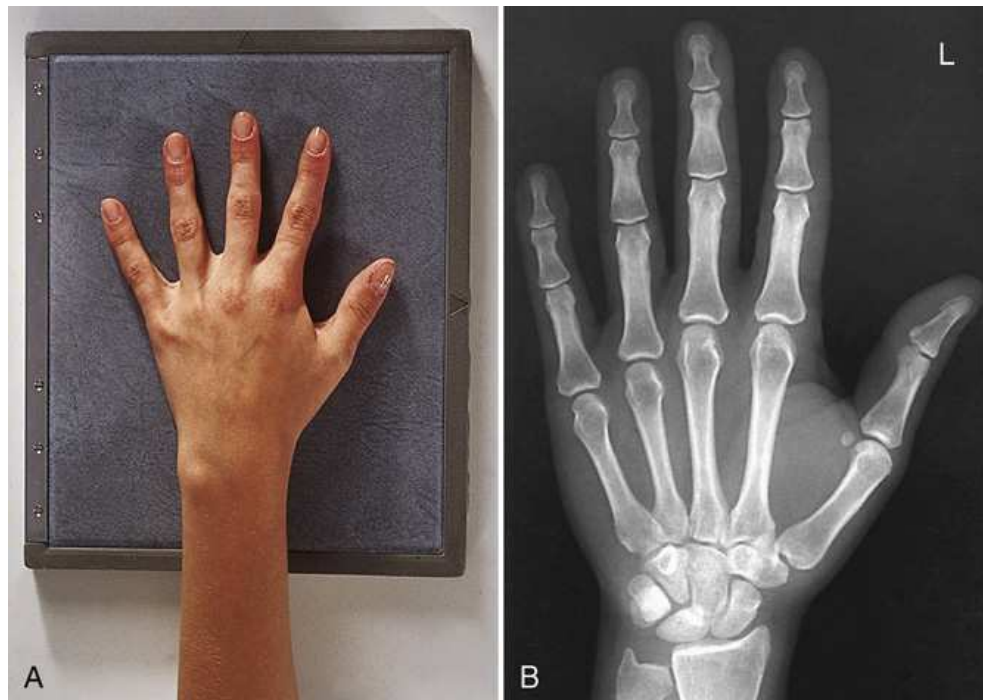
(A) Left hand positioned on IR. This view is from the perspective of the x-ray tube. (B) Radiograph of the left hand is displayed on the monitor in the same manner, with the digits pointed upward.
